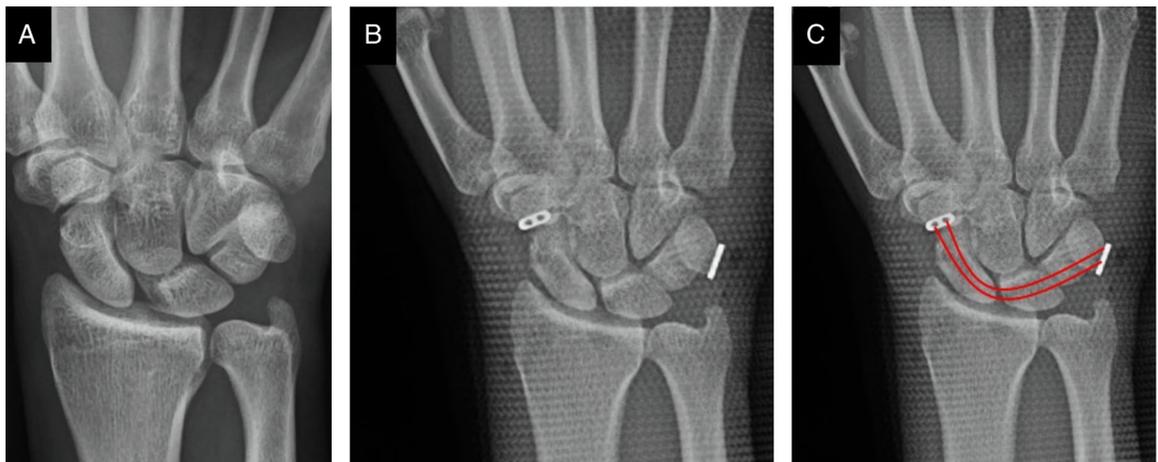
A, Preoperative x-ray showing complete scapholunate diastasis. B, Reduction of scapholunate diastasis with the suture-button system. C, Red lines represent the direction of the sutures.
